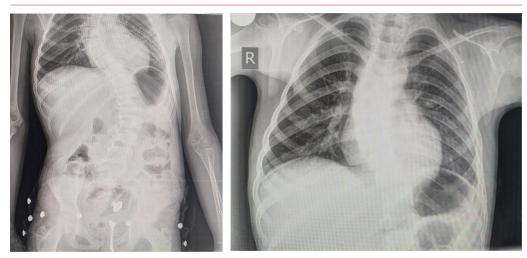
Shows a chest X-ray for case two at time of admission, which revealed cardiomegaly.
